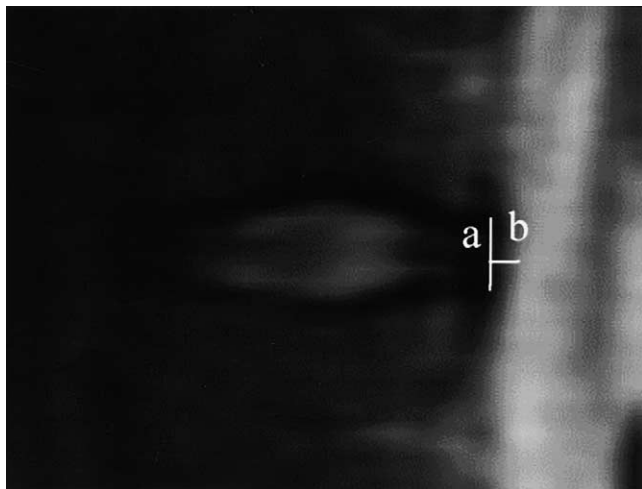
Example measurement of posterior disc bulge on MRI. First, line a was drawn connecting the two posterior edges of the endplates. A second perpendicular line b was drawn from the most posterior edge of the disc to the line.
